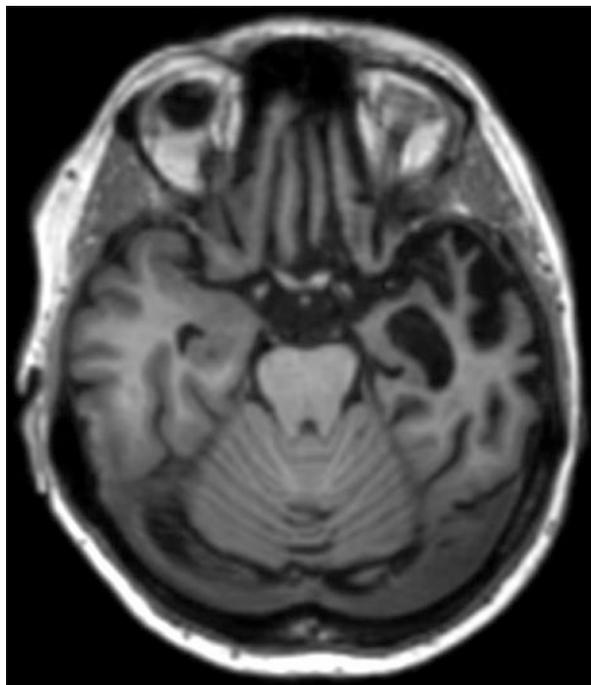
T1-MRI (*axial view*). Note profound cortical atrophy of the left anterior temporal lobe with involvement of the hippocampus
